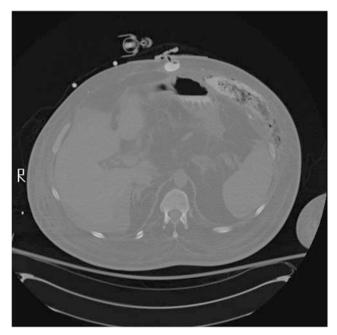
Computed tomography image of the percutaneous endoscopic gastrostomy tube outside of the stomach with a $21\,\mathrm{cm}\times2.8\,\mathrm{cm}$ left anterior abdominal wall collection consisting of air and contrast.
